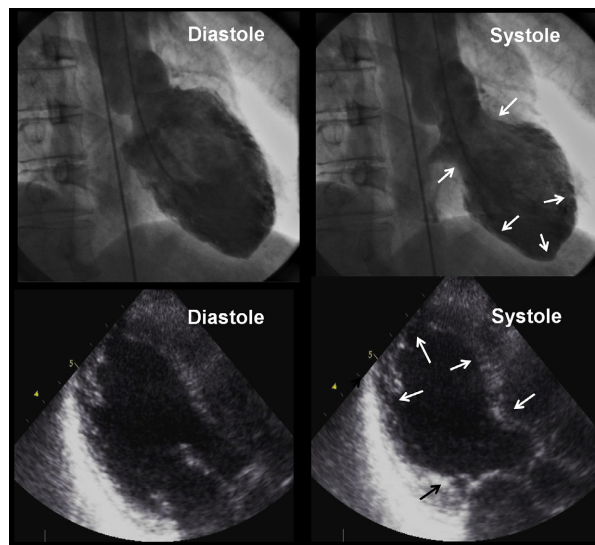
Laevo-cardiography (top) revealed severe wall motion abnormalities of the mid and apical portions of the left ventricle. Transthoracic echocardiography (bottom) demonstrated typical signs of an “apical ballooning” corresponding to TC.
